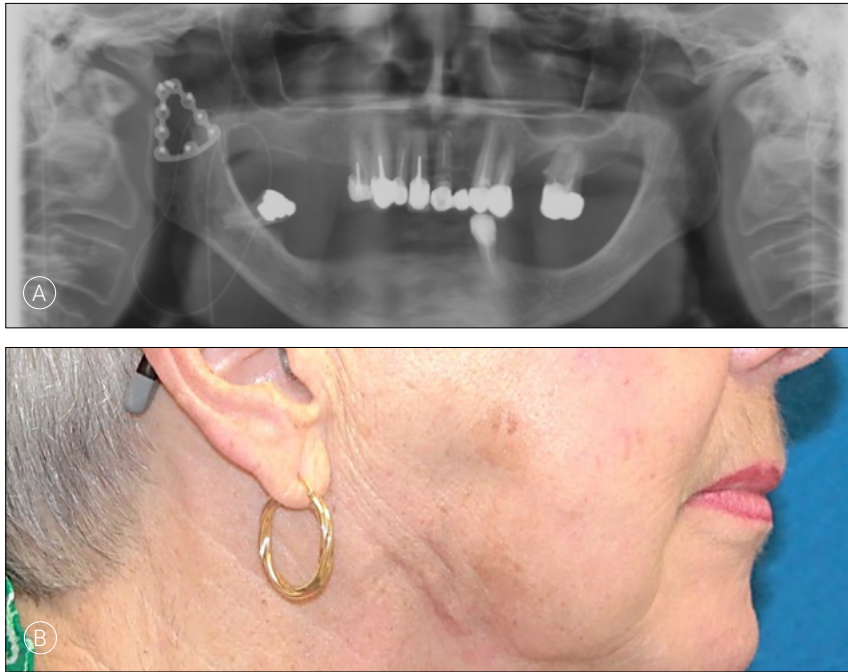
Postoperative findings. A. Orthopantomogram showing an anatomical reduction of the condylar base fracture. B. Postoperative appearance of the scar 10 weeks after the surgery.
